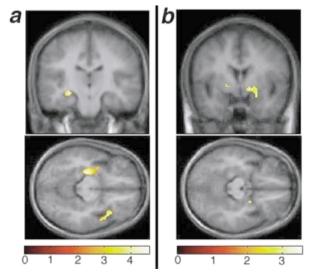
Rendering of statistical parametric maps (SPM). The SPM is displayed on coronal (top) and axial (bottom) slices in a neurological orientation (the right side of the brain slice corresponds to the right hemisphere). The areas of activation are all rendered on the average structural MRI images obtained from all 10 subjects. (a) Activations associated with the effect of winning (obtained by combining the increase of 'win' trials and the decrease of 'lose' trials). The coronal and the axial views show the activation in a region encompassing the left amygdala and hippocampal complex. The axial slice also shows the activation in the right inferior frontal gyrus. (b) Activations associated with the effect of losing in the right amygdala (obtained by combining the increase of 'lose' trials and the decrease of 'win' trials).
